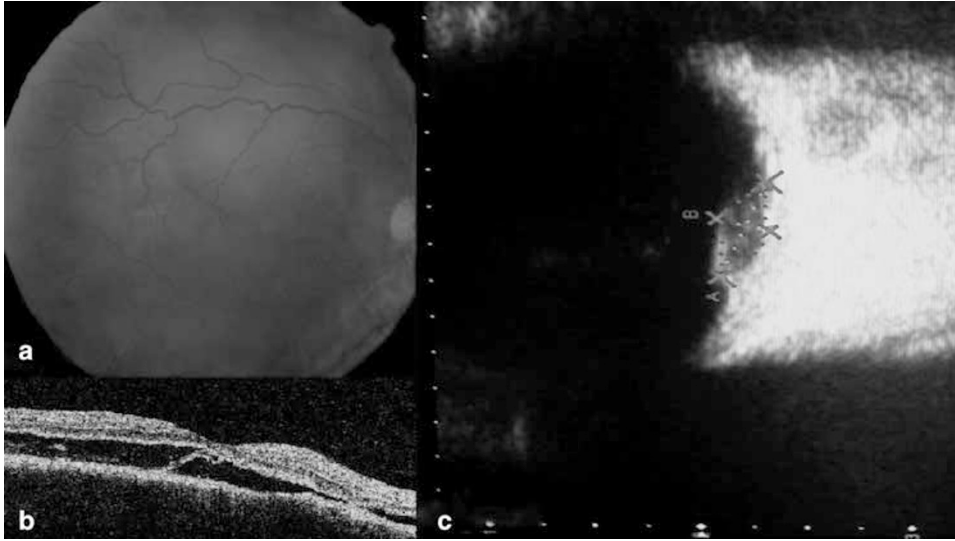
(a) Funduscopy 3 weeks after the injection of bevacizumab (4 mg). Size reduction of the yellowish mass. (b) OCT scan 3 weeks after the injection of bevacizumab (4 mg). Flattening of the serous retinal detachment. (c) B-mode ultrasonography 3 weeks after the injection of bevacizumab (4 mg). Choroidal mass with an extension of 6.4×2.3 mm.
